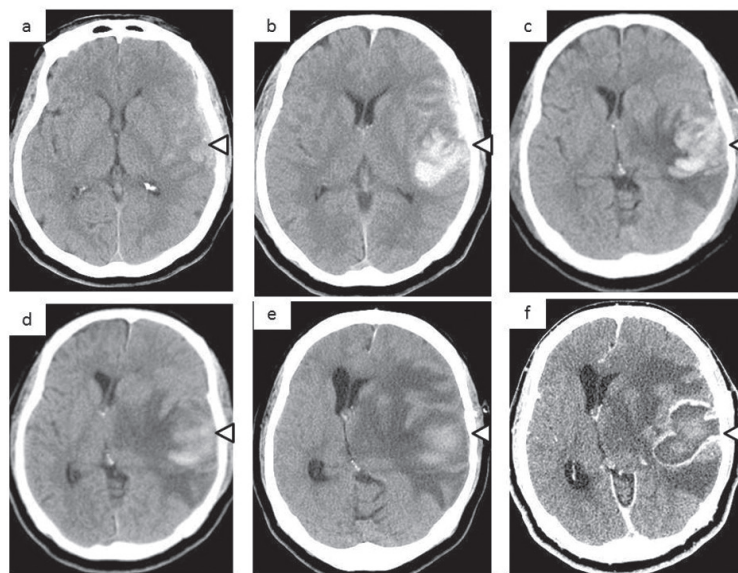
Serial changes in head computed tomography (CT). Head CT revealed the formation of hematoma (arrowheads). Brain edema had progressed continuously at least until 13 days after the injury. a: on admission; b: 3 hours after admission; c: hospital day 7; d: day 10; e and f: day 13 (plain and enhanced CT, respectively).
